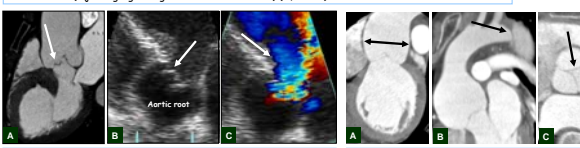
AAE with AR in a 36-year-old man. Multiplanar reformatted CT image (A) - Redundant right coronary cusp (arrow) with diastolic prolapse and coaptation defect. Echocardiographic images (B, C) - Eccentric severe AR due to prolapse of right coronary cusp (B, arrow) and a jet regurgitating into the left ventricle (C, arrow).
